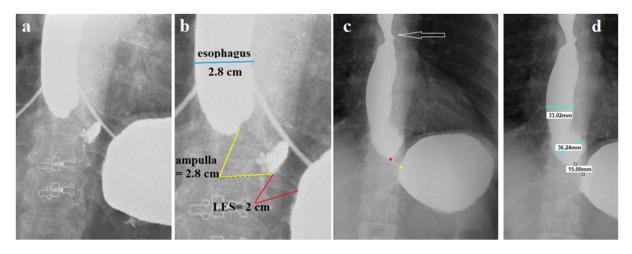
(a,b). X-ray studies of the EGJ with provocation high pressure in the stomach which was performed during a period of exacerbation of the disease. Significant expansion of the esophagus was found (2.8 cm vs. 1.5 cm in normal). After contraction of the phrenic ampulla, a small amount of barium remained in it in the form of a diverticulum on the left wall. The LES is shorter than normal (2 cm versus 3.6 cm). XIR = 1.4 (normal <1). (c,d). At re-examination 1.5 years later, the esophagus became wider and the length of the LES became shorter. XIR = 2.2.
